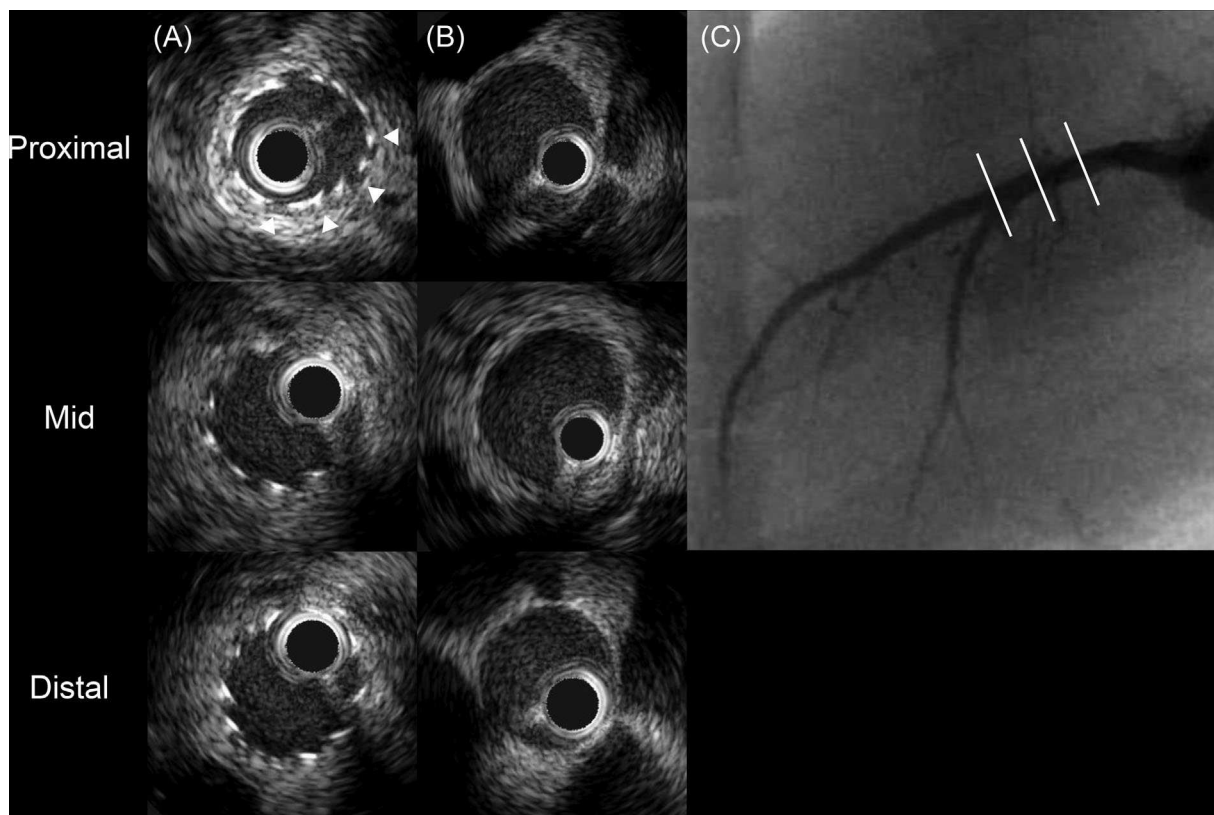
Representative IVUS findings after stent retrieval on the first day. Inappropriate expansion of the stents at the proximal site was confirmed by intravascular ultrasound (IVUS) (A, white arrow heads). We could not detect coronary dissection by IVUS after stent retrieval (B). Final angiography revealed absence of vessel rupture or occlusion (C)
